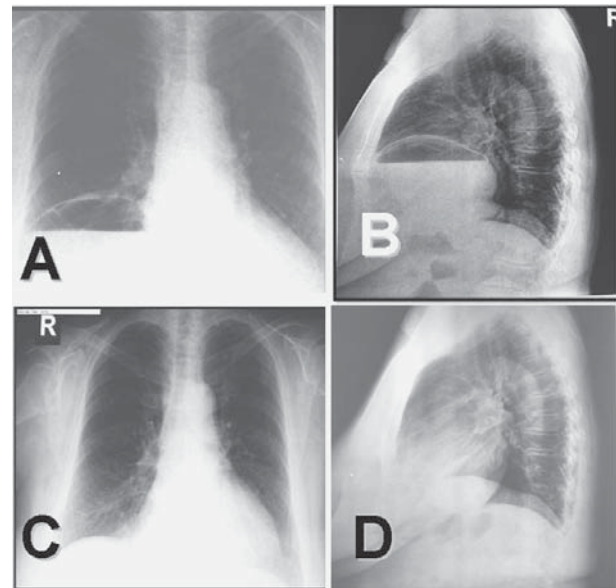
A: Chest x-ray showing unspecific changes of the right chest; B: profile chest x-ray showing tumor formation in the right chest, of unknown etiology; C and D: chest and abdominal multi-slice computed tomography showing Morgagni hernia.*
